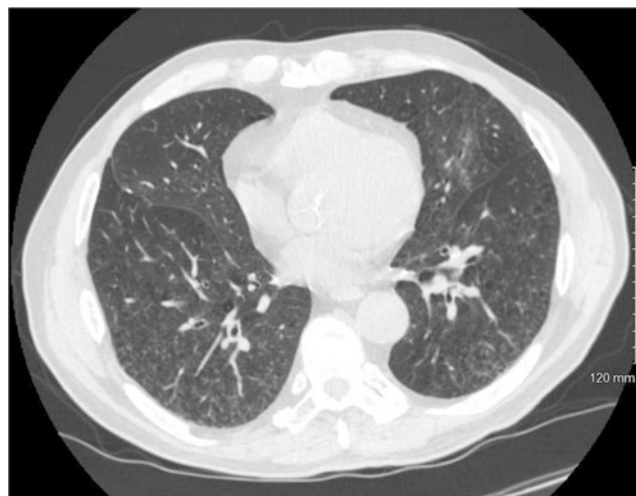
HRCT of patient. An axial high-resolution CT scan of the chest shows basilar centrilobular nodules and small cysts, present bilaterally. (Figure courtesy of Travis Kauffman, DO, University of Missouri Kansas City, Kansas City, MO)
